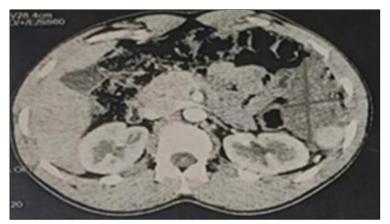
Axial abdominal CT-scan showing the intersplenorenal mass
